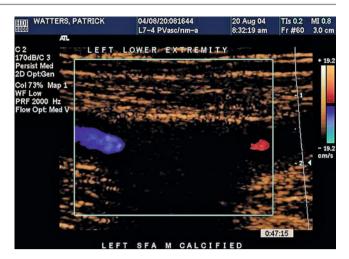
The lumen of this calcified segment of the superficial femoral artery cannot be assessed by ultrasound due to dense shadow obscuring the color flow signal
